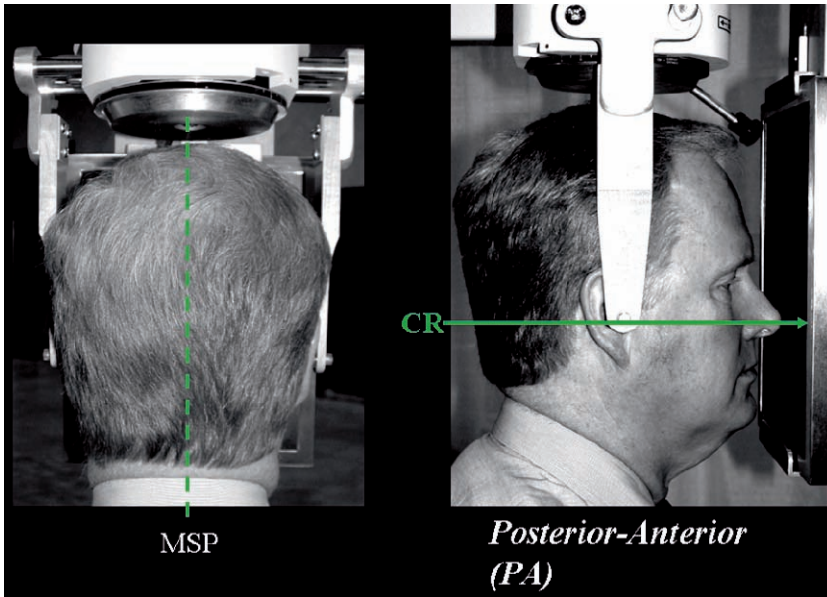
Posterior-anterior (PA) projection. The use of a cephalostat makes the radiographic image a cephalogram suitable for orthodontic analysis. *CR* Central ray, *MSP* midsagittal plane
